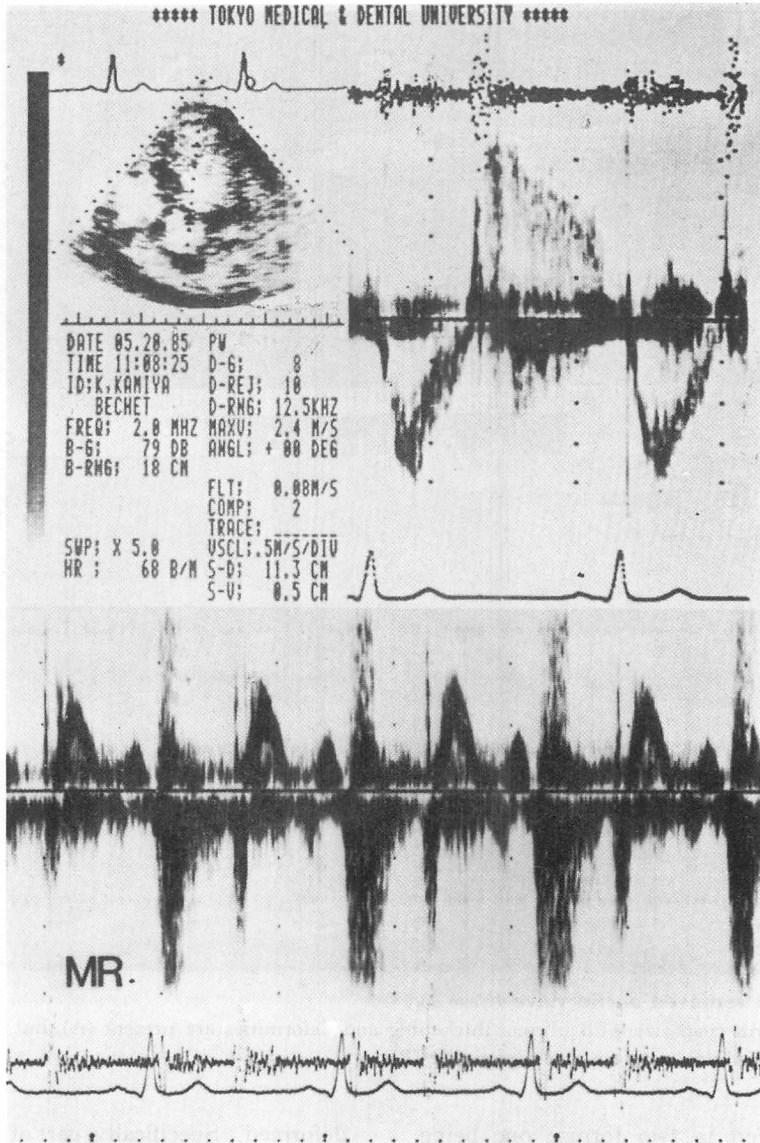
Doppler echocardiograms (Case 2).
